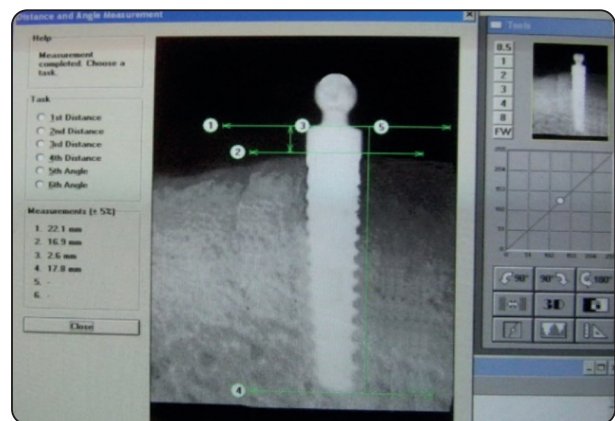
Crestal bone height measurement by digital radiography.
